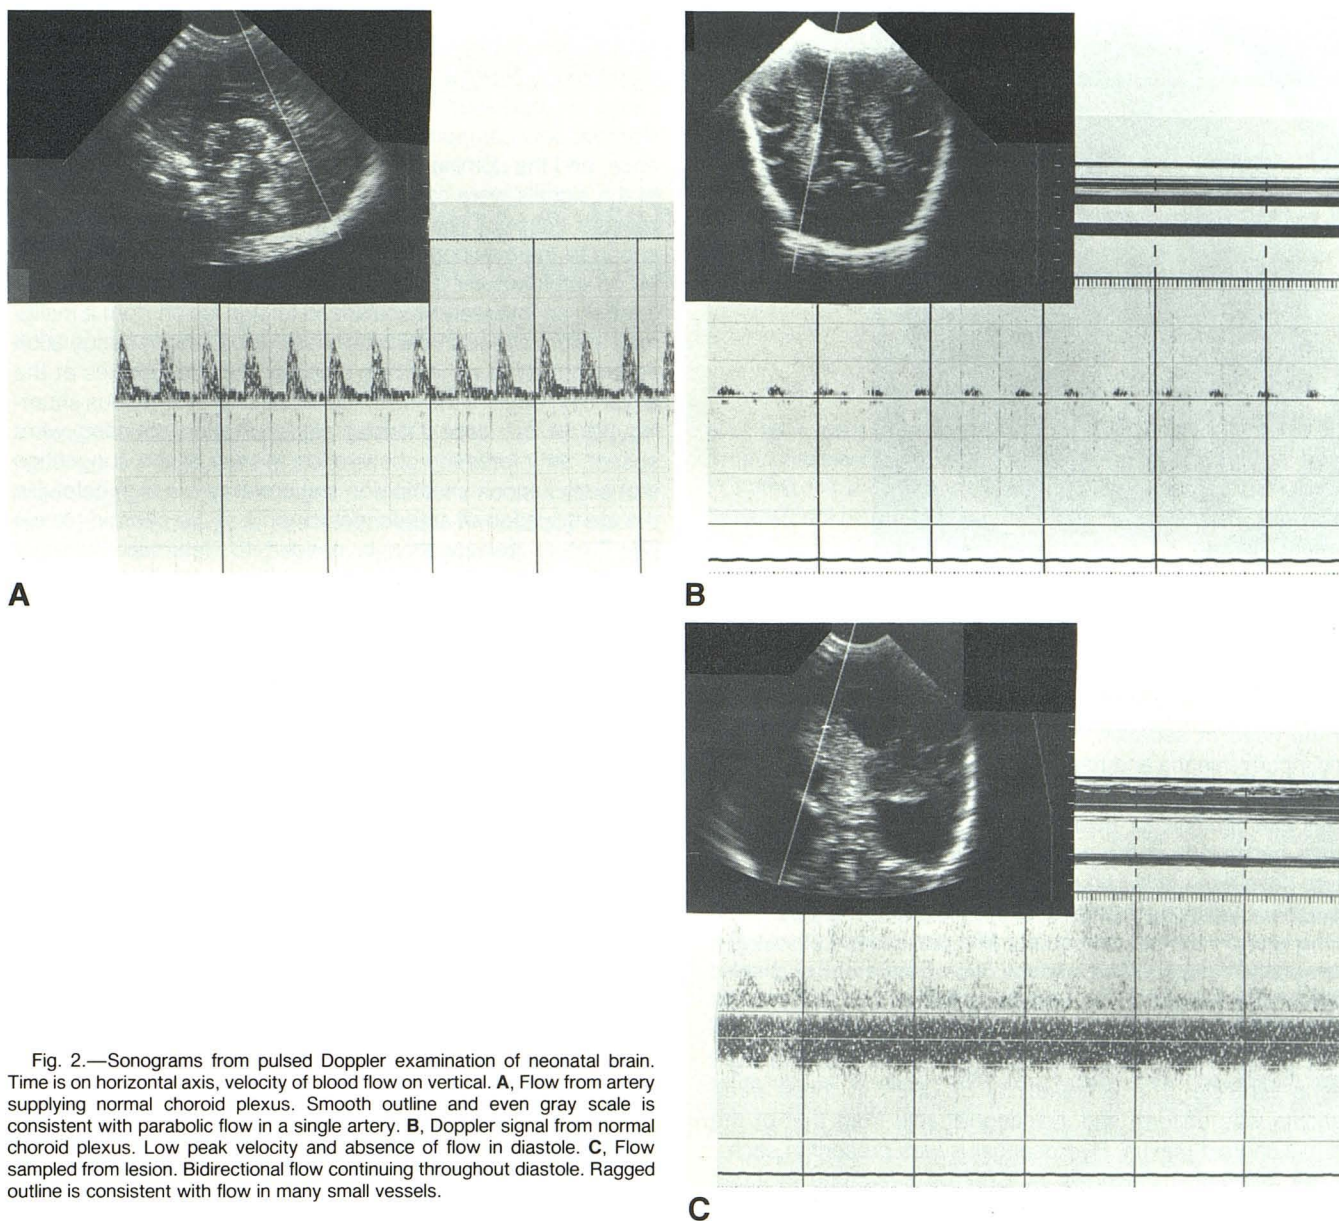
Sonograms from pulsed Doppler examination of neonatal brain. Time is on horizontal axis, velocity of blood flow on vertical. A, Flow from artery supplying normal choroid plexus. Smooth outline and even gray scale is consistent with parabolic flow in a single artery. B, Doppler signal from normal choroid plexus. Low peak velocity and absence of flow in diastole. C, Flow sampled from lesion. Bidirectional flow continuing throughout diastole. Ragged outline is consistent with flow in many small vessels.
